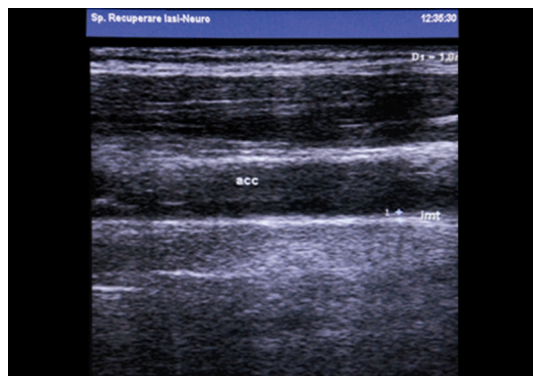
Carotid ultrasound (Siemens Acuson X300, 7 MHz linear probe) in a SLE patient: thickened cIMT (1 mm).
